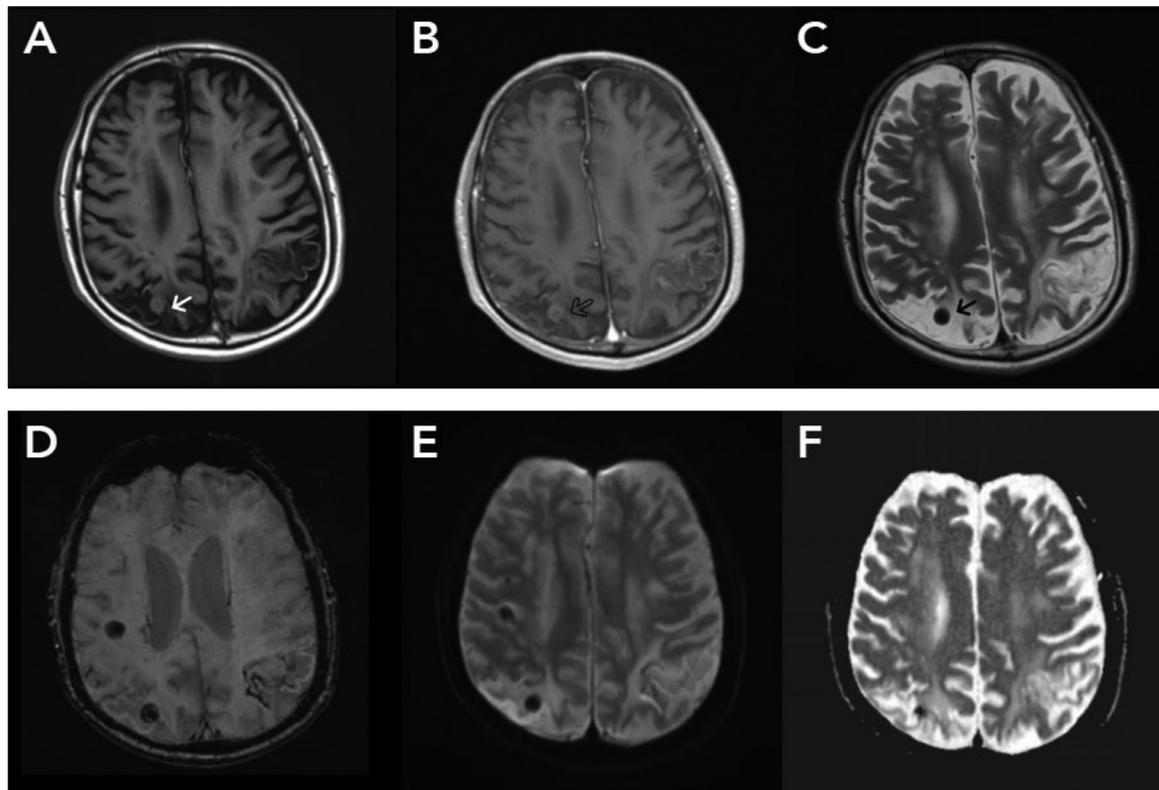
Granular nodular stage on axial view T1-weighted image (A), Postcontrast T1-weighted image (B), T2-weighted image (C), SWI (D), DWI (E), and ADC (F) showing single, spherical lesion with well-defined border, diameter of 0.90 cm at right subcortical occipital lobe with hypointense on T1-weighted image (A, white arrow), hyperintense rim on T2-weighted image (C, black arrow), ring enhancement (B, black arrow), and blooming artefact (D). No restricted area was seen within the lesion on DWI and ADC. (E,F).
